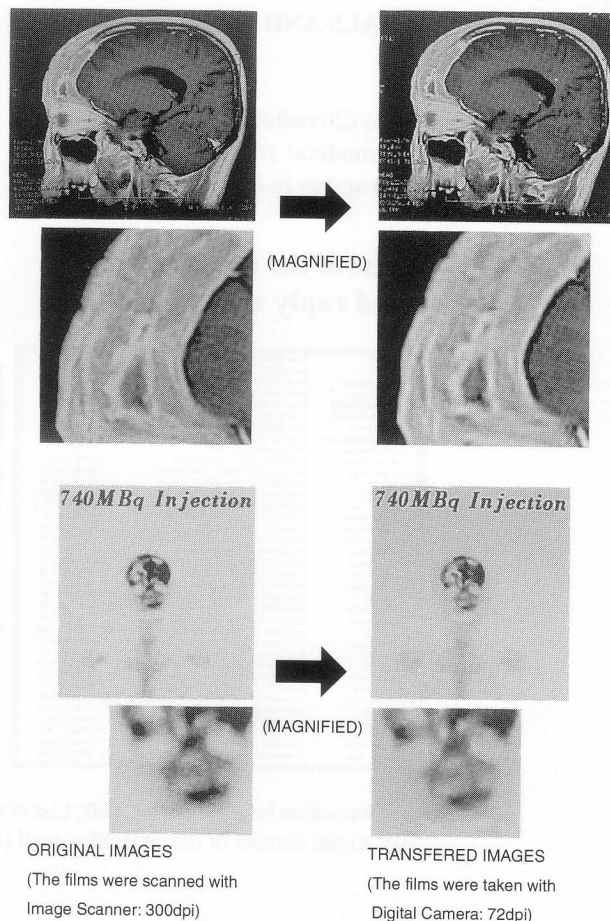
Representative original images (left) and transferred images with digital still camera (right) of MRI (top) and bone scan (bottom) in Case 4. The quality of the transferred images are good enough for discussion.
